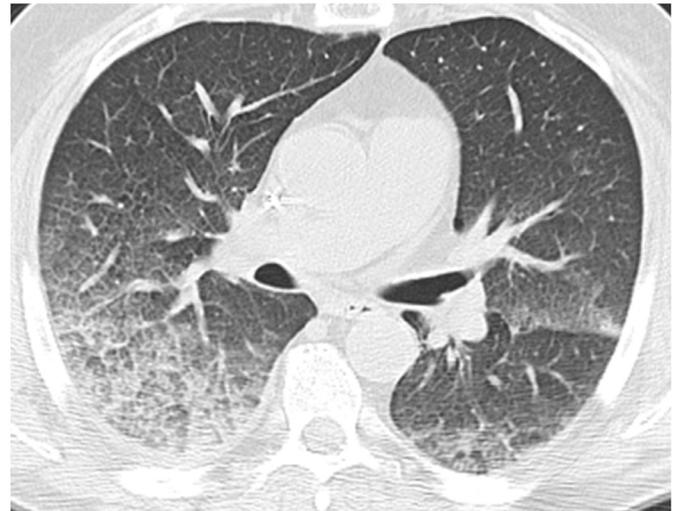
Interstitial pulmonary edema in a patient 10 days after HSCT. CT shows interlobular septal thickening, mild ground-glass opacities, and small pleural effusions.
